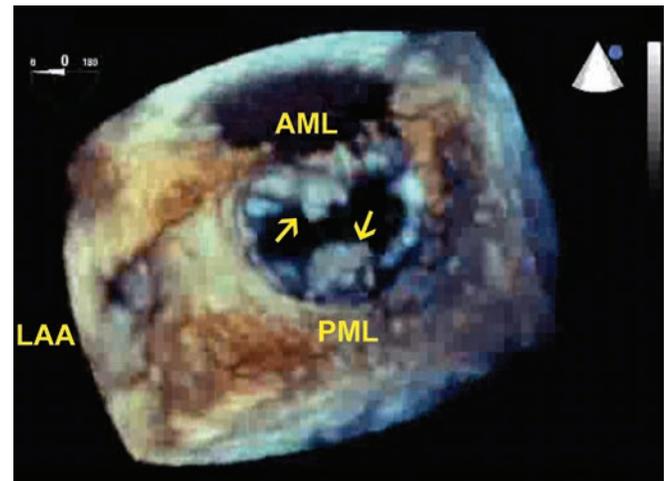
Transesophageal zoom 3D imaging of the mitral valve. Notice the masses attached to the mitral valve, at P2 and A2 scallops (arrows).
